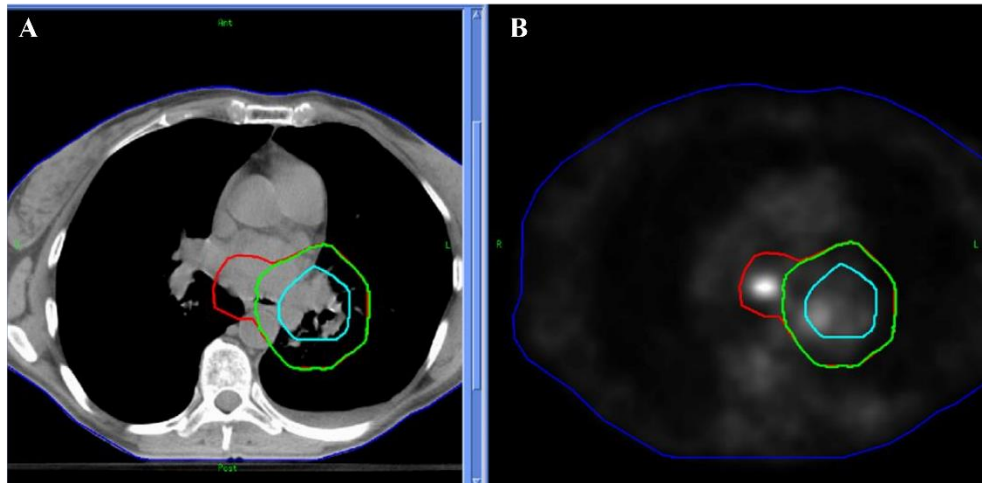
Image showing A) CT and B) PET images of a NSCLC treatment plan. Original PTV drawn on CT shown in green contour, with red contour showing extension of PTV after PET showed involvement of a paraesophageal lymph node in the mediastinum.¹¹
